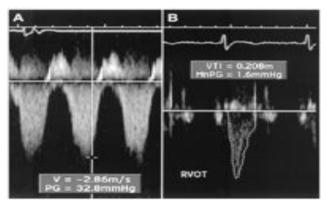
Images showing peak tricuspid regurgitant velocity (TRV) and right ventricular outflow velocity time integral (VTIR-VOT) in a patient with normal pulmonary vascular resistance (PVR). (A) TRV is 2.86 m/s. (B) VTIRVOT is 20.8 cm. The ratio of TRV/ VTIRVOT = 2.86/20.8 = 0.1375. This patient's invasive PVR measurement was within 0.4 WU of the echocardiographic value (PVRCATH = 1.3 WU). PVRECHO = PVR in WU calculated based on the linear regression equation in which a value for PVR in WU was modeled based on TRV/ VTIRVOT. PVRCATH = invasive PVR
